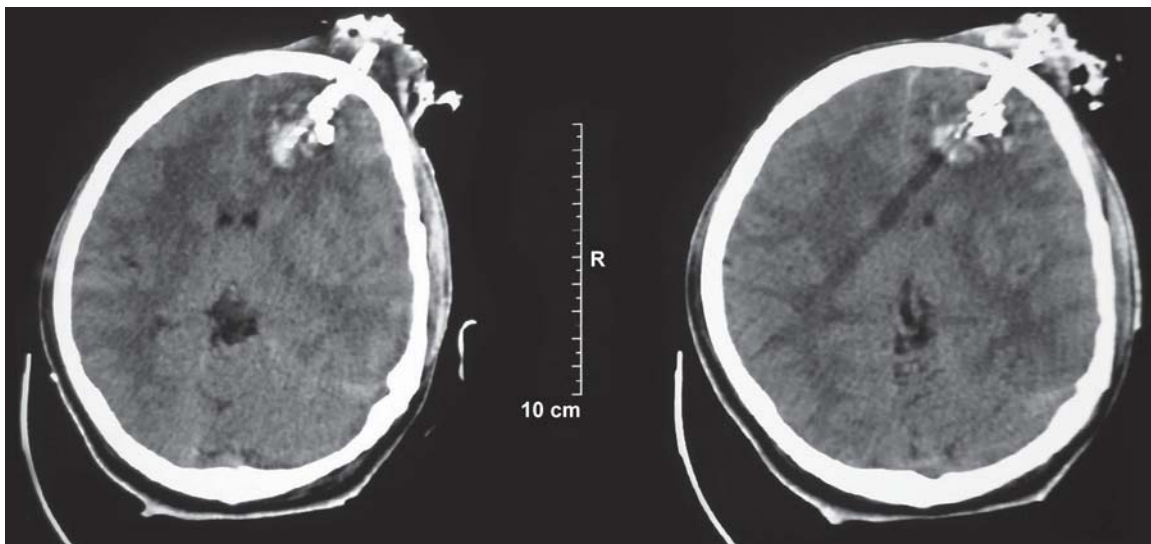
CT scan showing penetrating injury with foreign body in the brain
